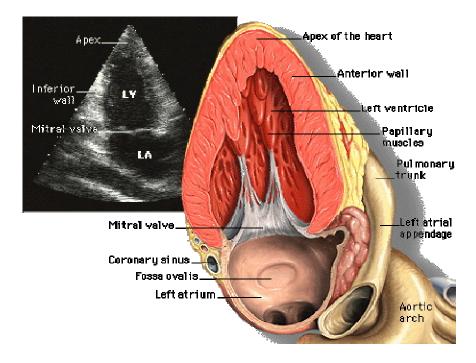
Apical 2-Chamber
